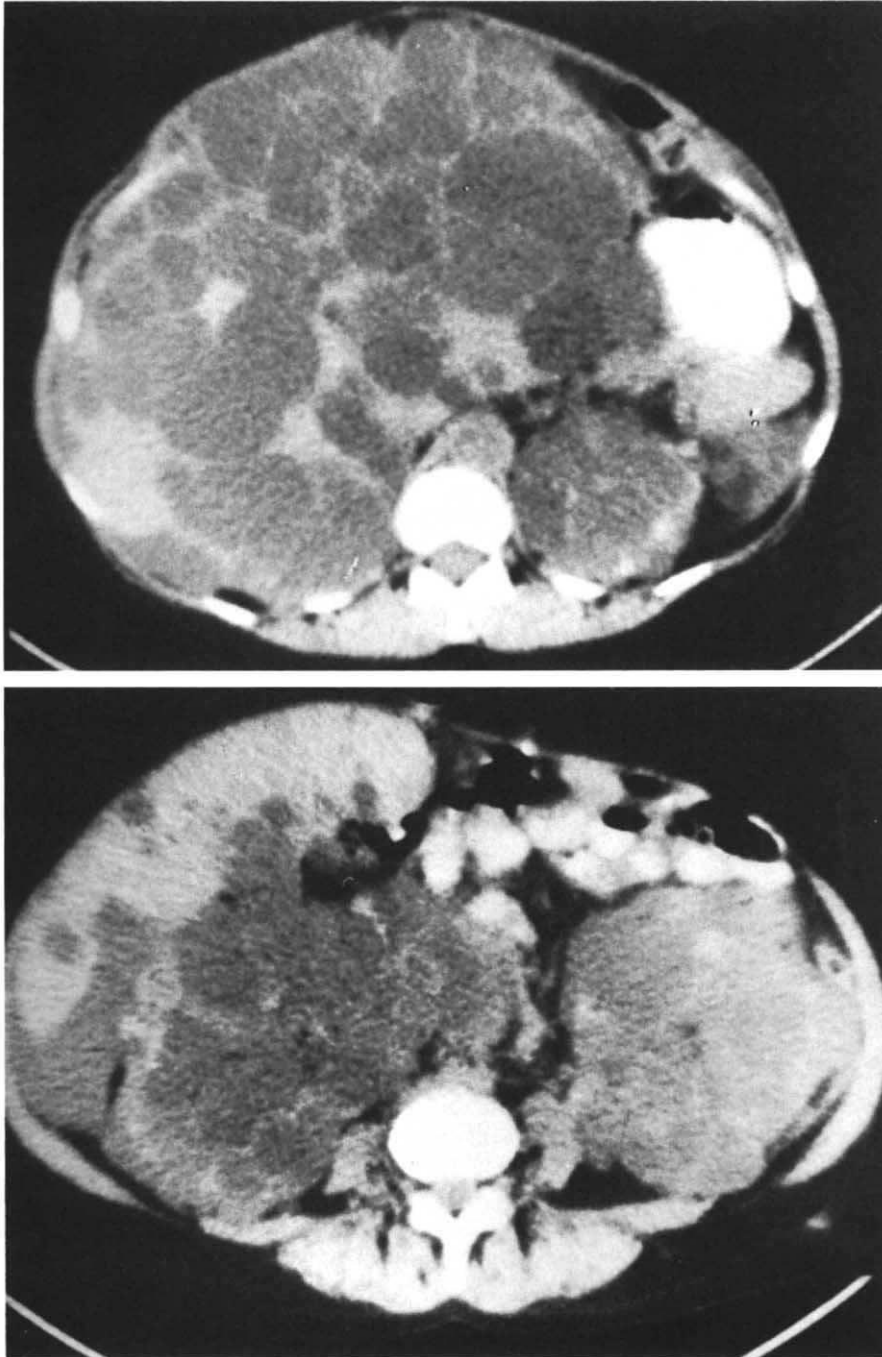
(Upper) CT scan demonstrating a massively cystic liver and cysts in the upper pole of the left kidney. (Lower) Lower level of the same CT scan demonstrating cysts in both markedly enlarged kidneys and a few cysts in the liver.
